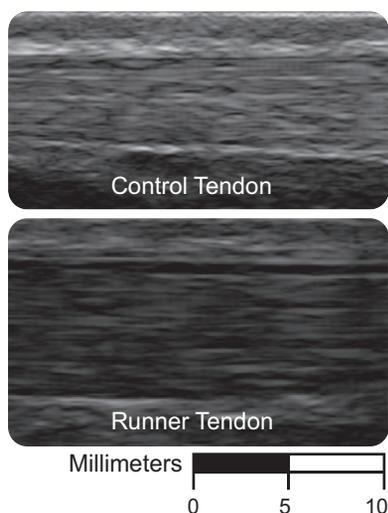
Major differences between the runner and control group can be seen when comparing these tendons under ultrasound. Runner tendon appears visibly thicker and less echogenic than control tendon.
